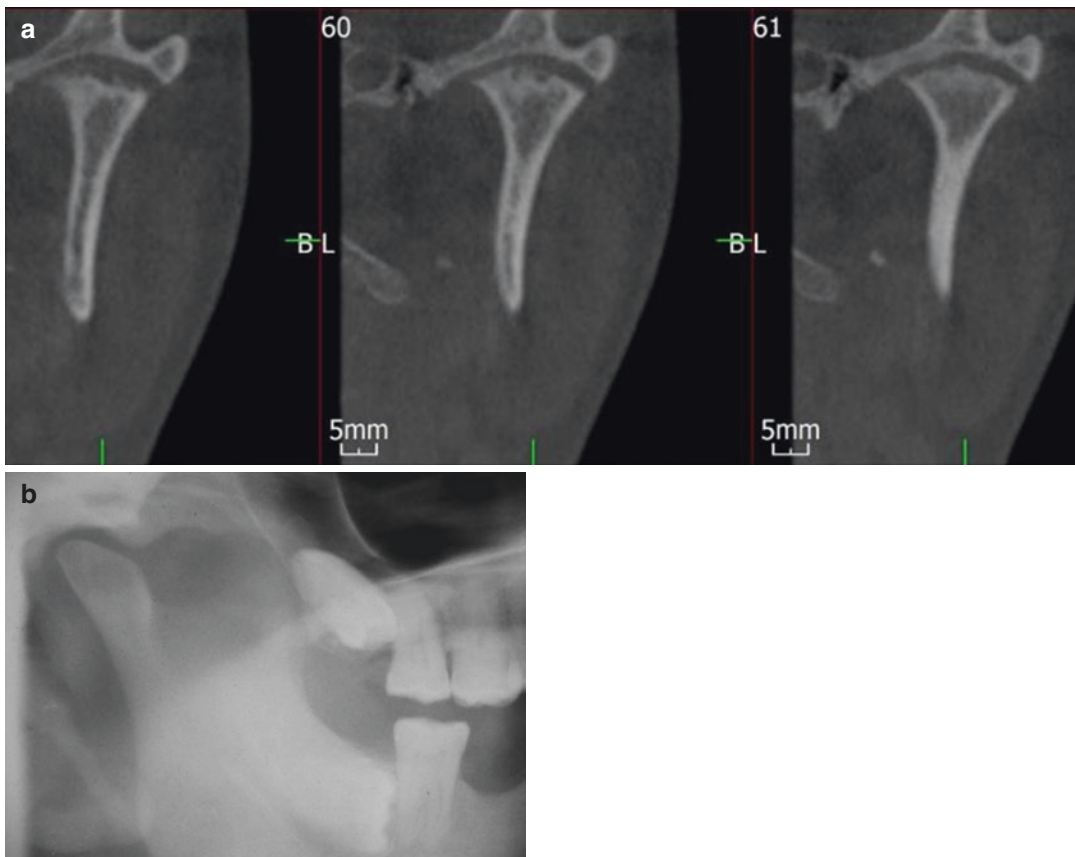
(a) Coronal CT images showing alteration in condylar head anatomy and round radiolucent region (Ely’s Cyst). (b) Articular surface of condyle showing flattening and subcortical sclerosis
